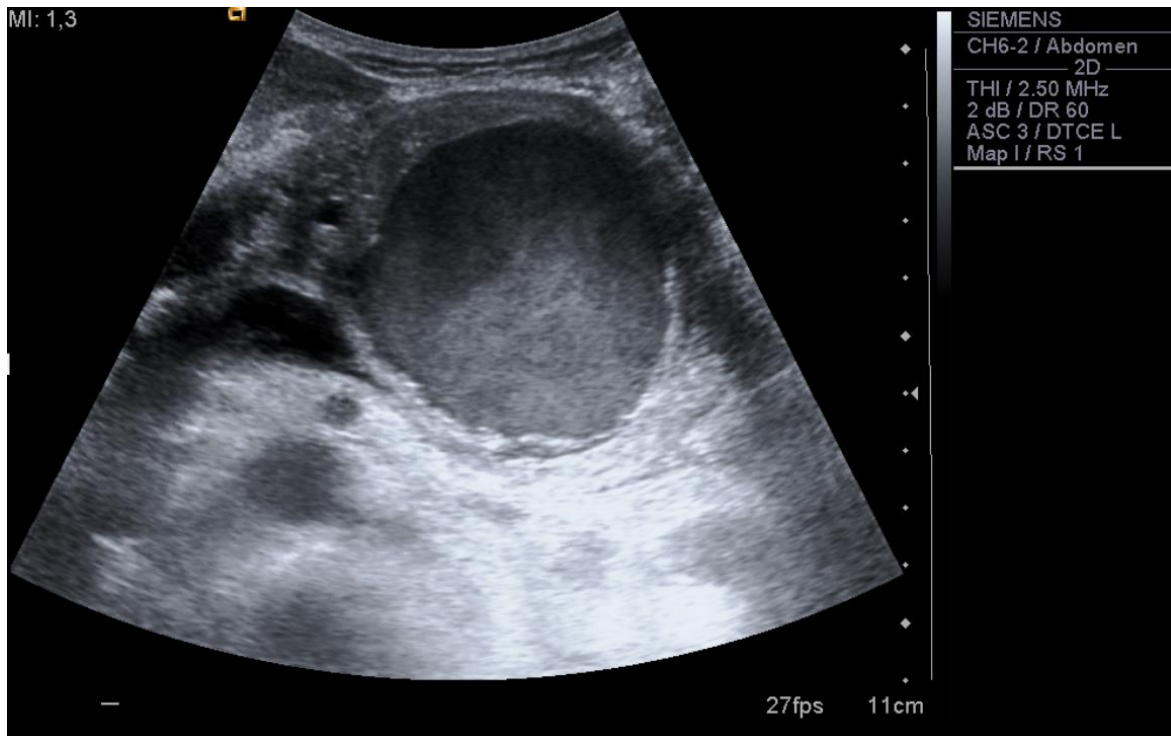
Ultrasound image of SAP
